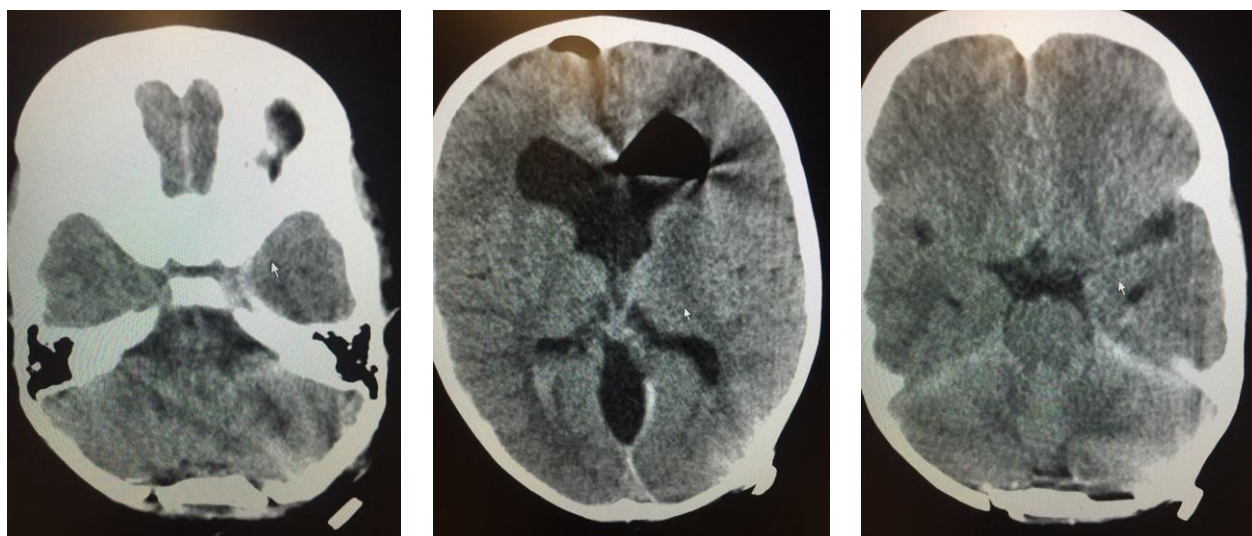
Early postoperative axial brain CT scan showing resection cavity
